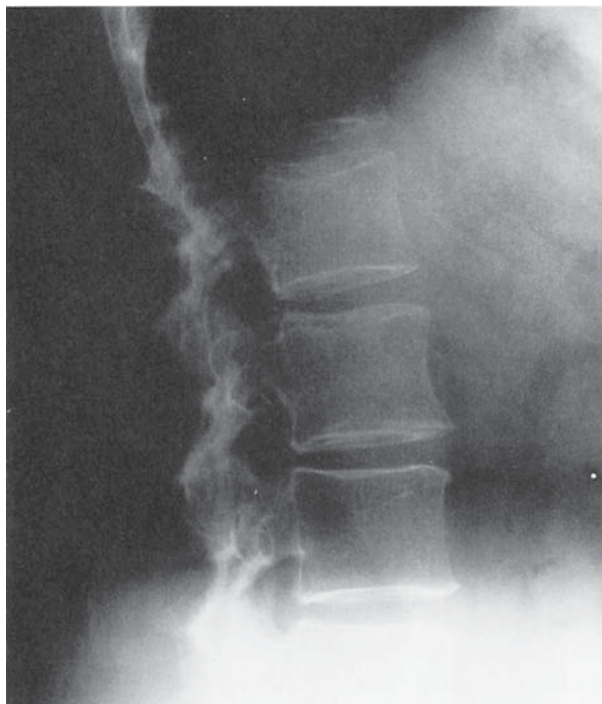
Quantitative spine morphometry. The vertebrae on this lateral lumbar spine X-ray demonstrate marked accentuation of the vertical trabecular pattern and thinning of the cortical shell. This is a Grade 2 spine.
